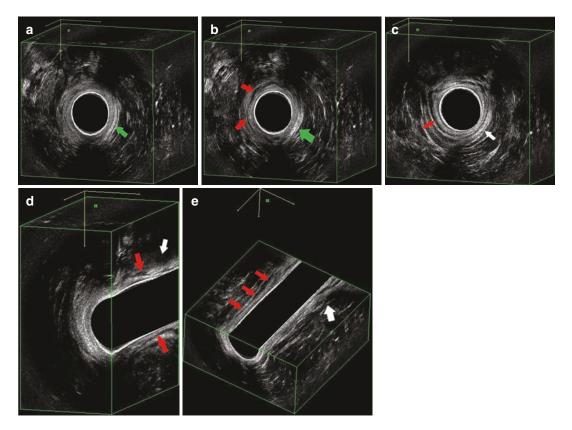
3D endosonographic pattern of a 17-year-old female patient with VACTER syndrome and faecal incontinence
